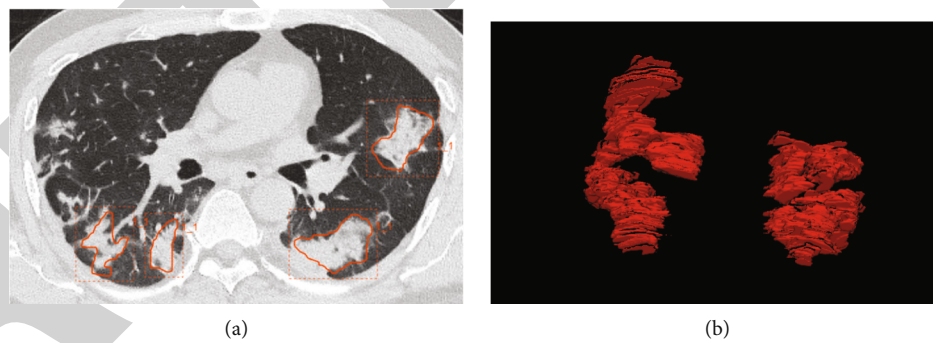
A case of confirmed severe COVID-19. A 45-year-old male presented with a 12-day history of fever, cough with expectoration, and mild dyspnea. (a). CT imaging revealed multiple consolidation with symmetric distribution in both lungs. The area of the lesions was delineated on the axial. (b) The reconstructed images.
